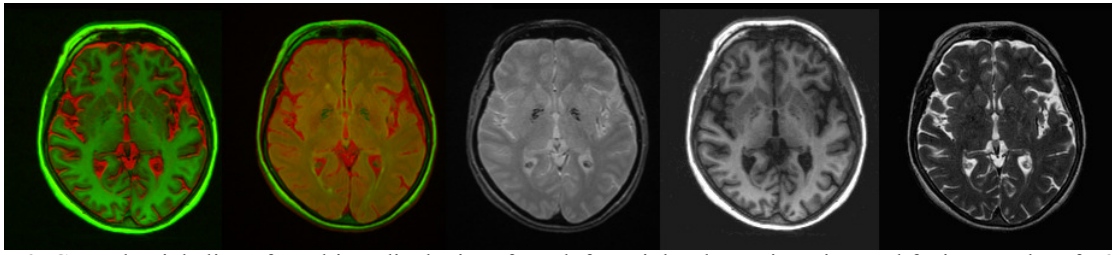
Central axial slice of a subject displaying, from left to right, the registration and fusion results of T2W and T1W, the result of the same process using T2*W and FLAIR images, the correspondent T2*W, T1W and T2 images, showing a mineralised basal ganglia.
